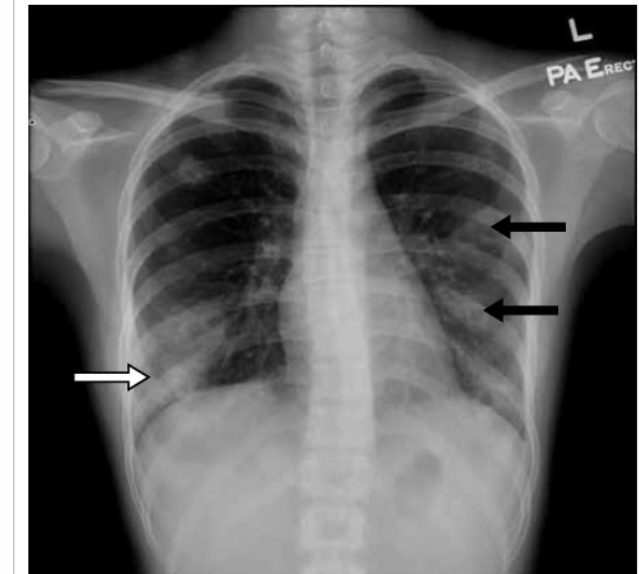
Chest X-ray revealing multiple cavitary lesions of variable size in the bilateral lung fields with no zonal predominance (black arrows)
